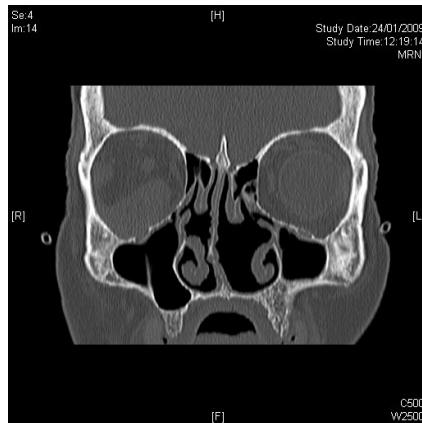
Coronal CT scan showing a right postero-inferior intraorbital soft tissue mass, involving the lateral and inferior recti muscles, which is stretching the optic nerve and extending into the maxillary sinus, pterygopalatine fossa and infratemporal fossa
